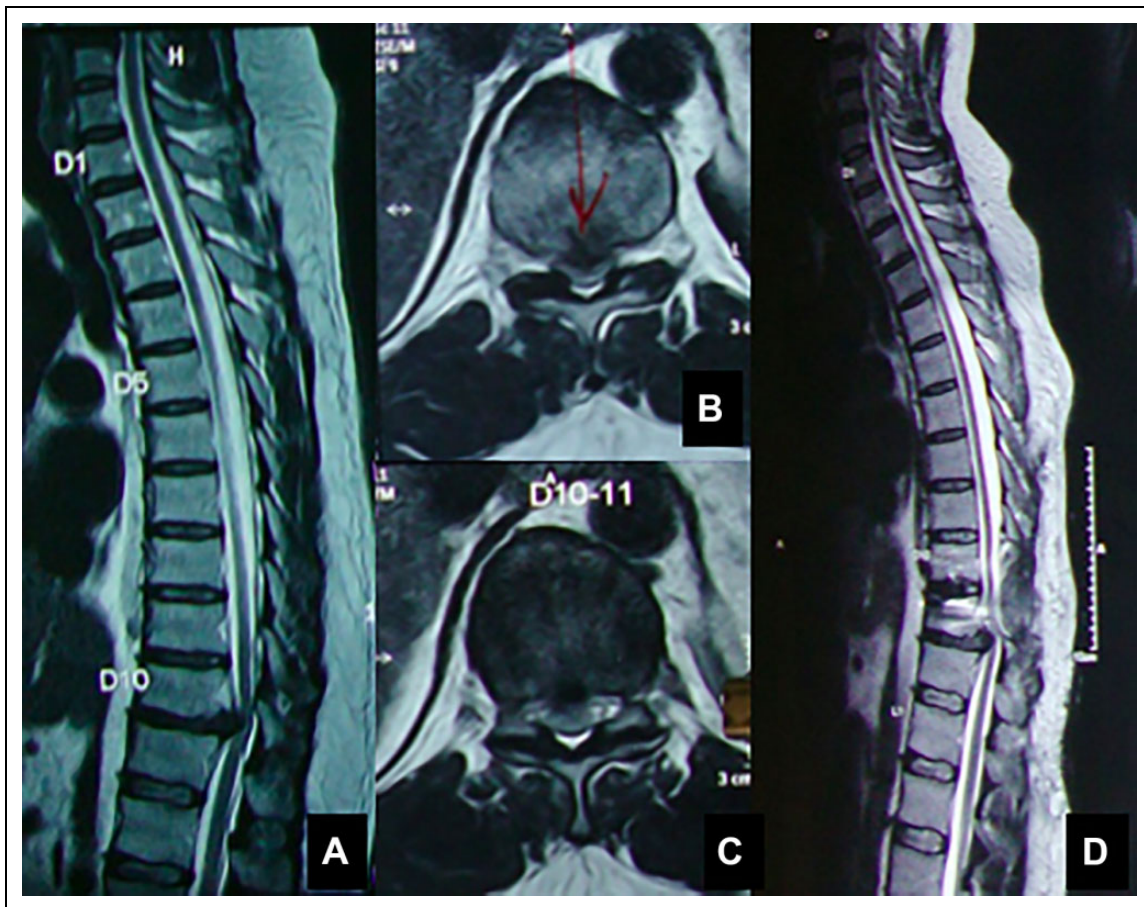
(A, B, C) Magnetic resonance imaging (MRI): sagittal partial film, axial T2 and T1 sequence that had marked the target level as T10-T11. Surgery was done on correct counting on radiographs and C arm. Postoperative patient had deficit with missed level which was revealed as T11-T12 in the postoperative full-length screening MRI (D).
